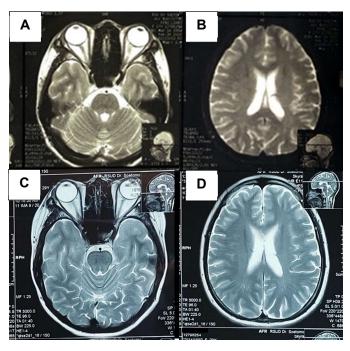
A and B MRI Brain 1,5 T on the first attack with OS Optic Neuritis and no sign of MS in brain area. C and D Brain MRI 3T with contrast on April 30th, 2021 with multiple lesions near left lateral ventricle T1 hypointense and T2 hyperintense, and left centrum semiovale isointense at T1W1/T2W1, hyperintense at T2, FLAIR no contrast enhancement
